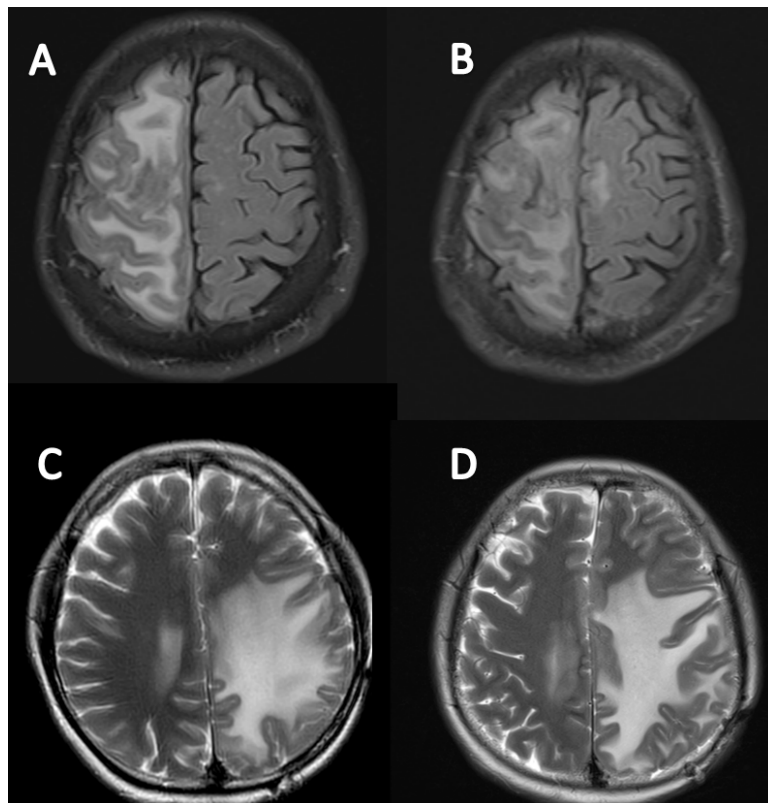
Case 1: RE appeared after SRS surgery for meningioma, and after receiving BEV adjuvant treatment, the therapeutic effect (SSF) was achieved. Figure 3A: Magnetic resonance FLAIR imaging showed large areas of oedema and radiation damage during the RE period after SRS. Figure 3B: Magnetic resonance FLAIR shows that after 6 cycles of BEV-assisted ASM treatment, oedema is reduced, and the range of radiation damage is reduced. Case 2: After SRS surgery for meningioma, RE appeared, and after receiving BEV adjuvant treatment, the treatment effect (SSR) was achieved. Figure 3C: Magnetic resonance T2 imaging showed extensive oedema during the RE period after SRS. Figure 3D: After 8 cycles of BEV supplementation therapy, oedema regressed and reached SSR
